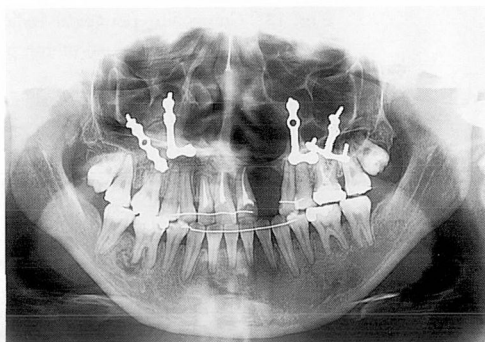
Radiograph reveals the immediate post surgical condition. (case 3)
